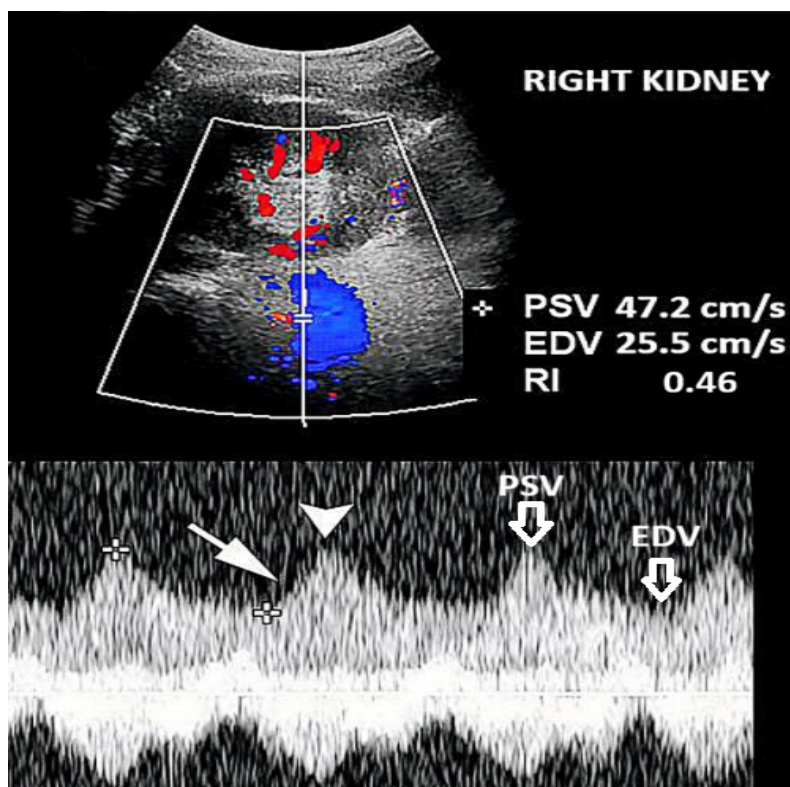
The USG Doppler image shows parvus tardus waveform in right middle interlobar artery and RI value of 0.46.
